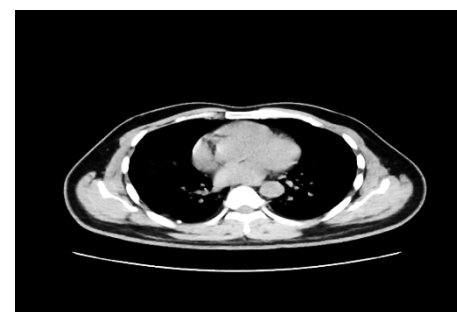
This Chest CT is associated to a 40-year-old man sick with severe appendicitis as primary experimental assessment because he had fever and right iliac fossa soreness and there weren't any marks of respiratory indications. The CXR pictures taken were uncertain of COVID-19 virus thus later in the chest, tummy and pelvis CT scans, the severe appendicitis and also common CT appearances of COVID-19 were discovered [53, 54].
